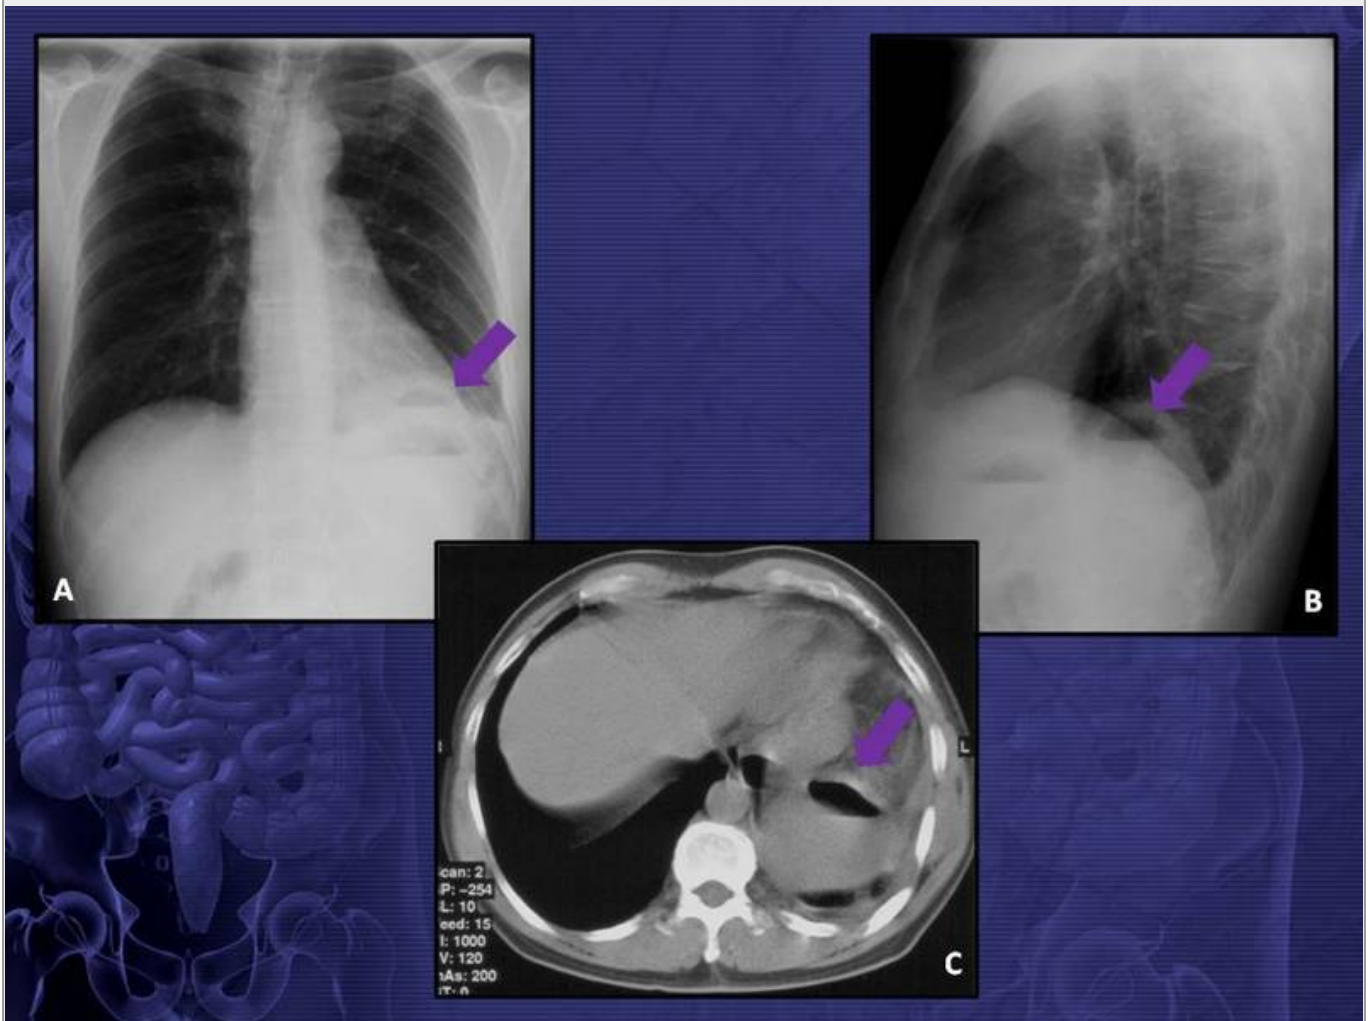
Frontal (A) and lateral (B) chest radiographs show an air-fluid level just below the elevated left hemidiaphragm. Note the normal gastric air bubble in its regular position. (C) CT scan was diagnostic for a left subphrenic abscess.
